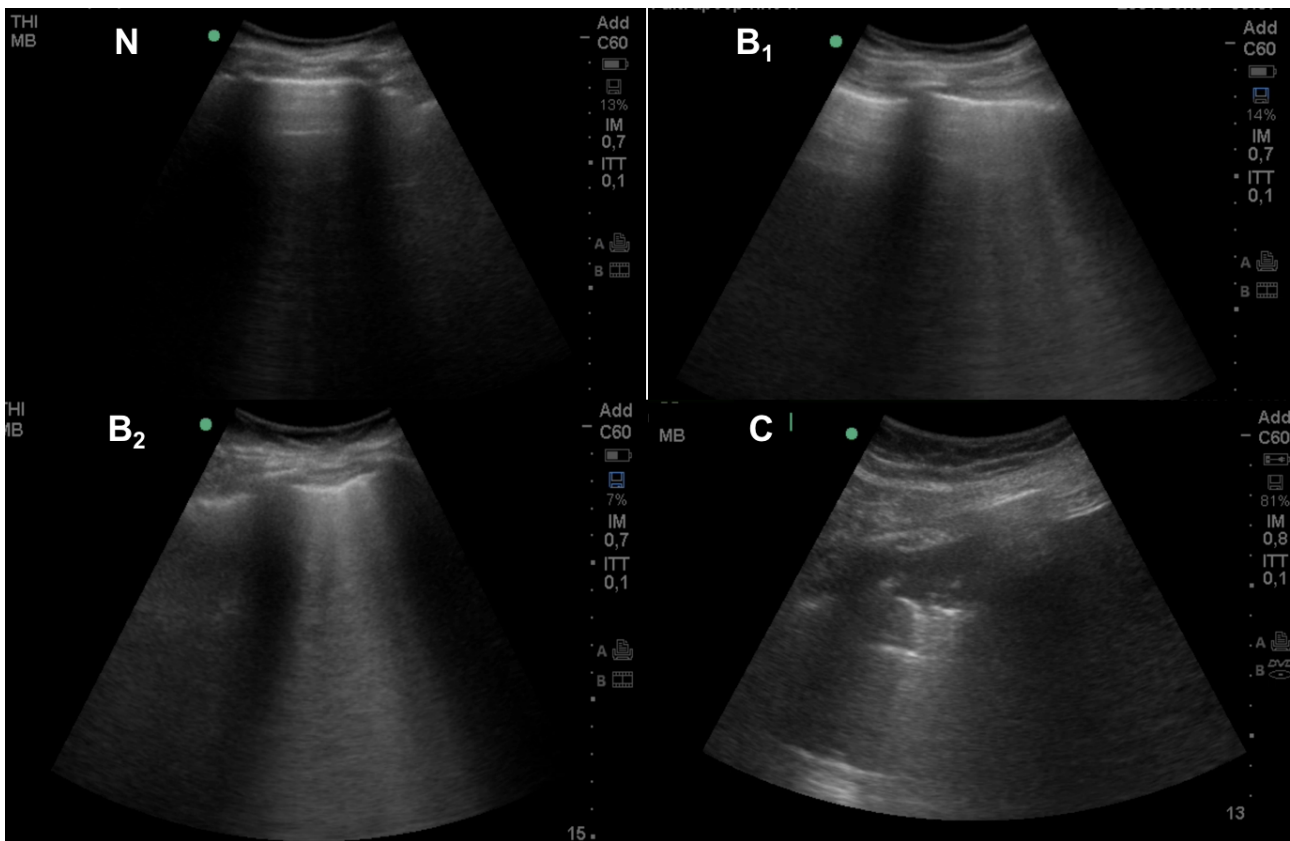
Lung ultrasound patterns. N = normal aeration; B₁ = moderate loss of aeration; B₂ severe loss of aeration; C = consolidation pattern.
